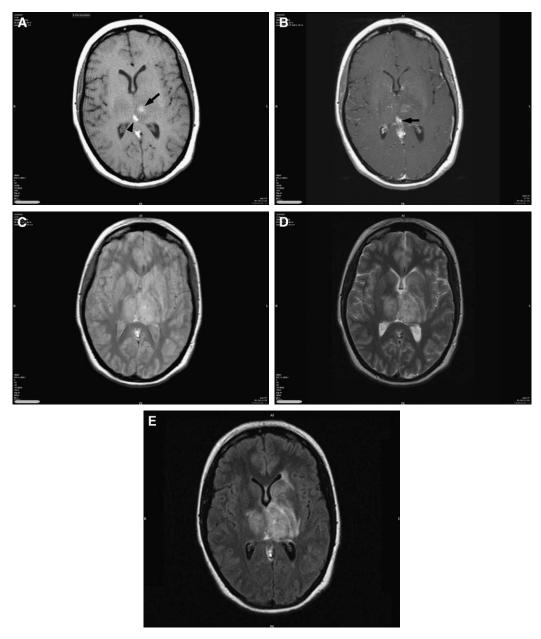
A 23-year old patient with an internal cerebral vein and straight sinus thrombosis causing recent venous infarcts. The dramatic sensitivity of FLAIR sequences compared with other spin echo (SE) techniques is demonstrated. (A) Axial T1-weighted SE image through the level of the thalami demonstrates a small amount of high signal intensity in the left thalamus consistent with a recent hemorrhage in the Met-hemoglobin form (arrow). There is also high signal intensity just posterior to this in the great vein of Galen consistent with thrombosed Met-hemoglobin (arrowhead). (B) After gadolinium enhancement, there is some minimal enhancement of congested veins of the thalami and left basal ganglia as well as slow flow in the vein of Galen (arrow). (C) Proton-weighted fast SE image yields little contrast between the areas of venous infarction and surrounding brain. (D) Axial T2-weighted (T2W) SE image demonstrates swelling of the thalami bilaterally, more so on the left side. (E) Axial T2W FLAIR image dramatically highlights the extent of the vasogenic edema in the left caudate nucleus and the thalami bilaterally as well as in the internal capsule on the left.
